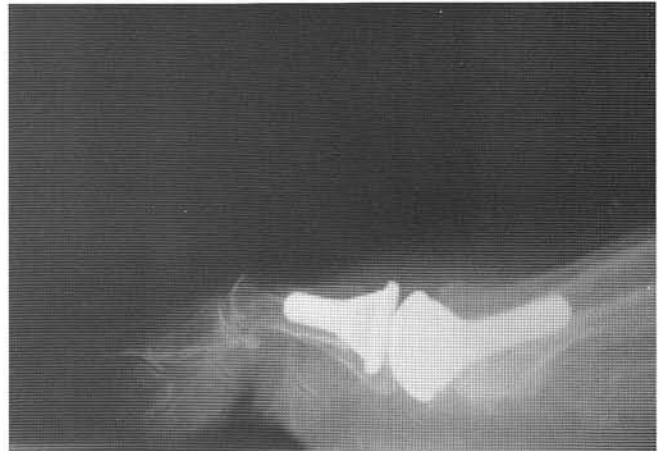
Lateral x-ray demonstrating how the cone angle directs the articular surface too far dorsally.
